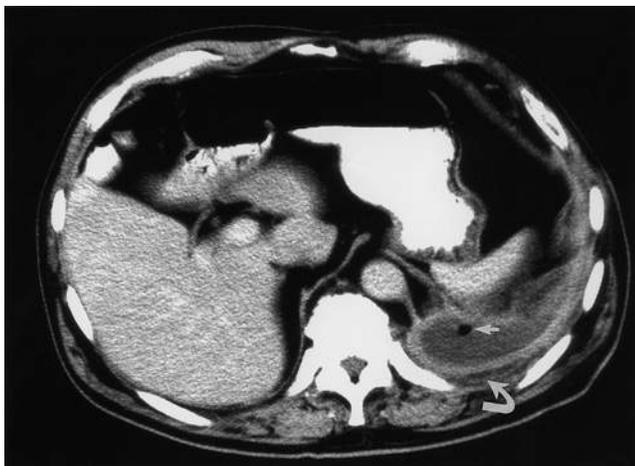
Empyema. Cross-sectional computed tomography image shows an elliptic pleural fluid collection surrounded by thickened enhancing pleura (split pleural sign). The presence of the gas bubble (*short arrow*) within the fluid and the thickened extrapleural subcostal tissues (*curved arrow*) is strongly suggestive of empyema.
